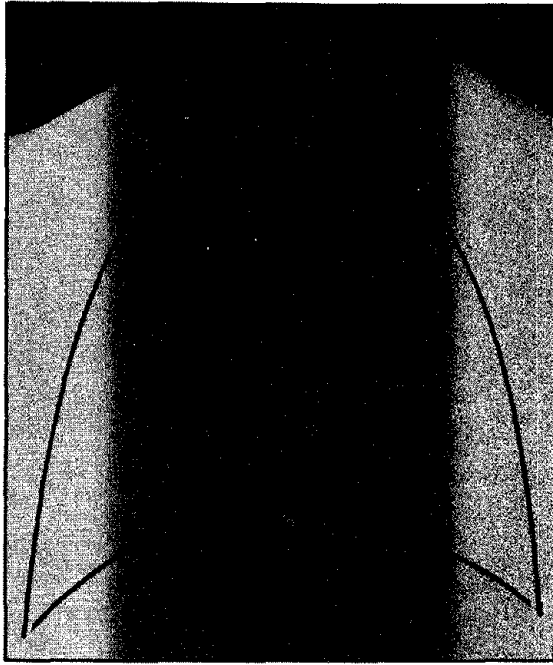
(left). Some common difficulties associated with the use of a Bucky or grid: improper grid focal range. If a 40-inch focal film distance is used instead of a 72-inch, a bilateral cutoff occurs on both lateral aspects of the grid. Often an upright Bucky is used for high kilovoltage chest radiography. In general, the upright Bucky of older radiographic rooms contains a grid focused for conventional radiography as opposed to teleroentgenography (72-inch focal film distance or greater). It is relatively easy to remove the grid and check the manufacturer's label regarding grid focal range and grid ratio.
